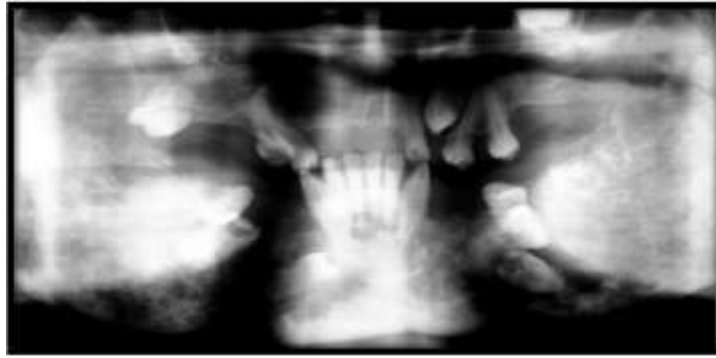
Orthopantomograph of the same patient as in Figure 3, revealing radiographic alterations characterized by greater radiopacity resulting from bone deposition and confirming the lack of involvement of the condylar regions. Note the malpositioning and retention of teeth.
